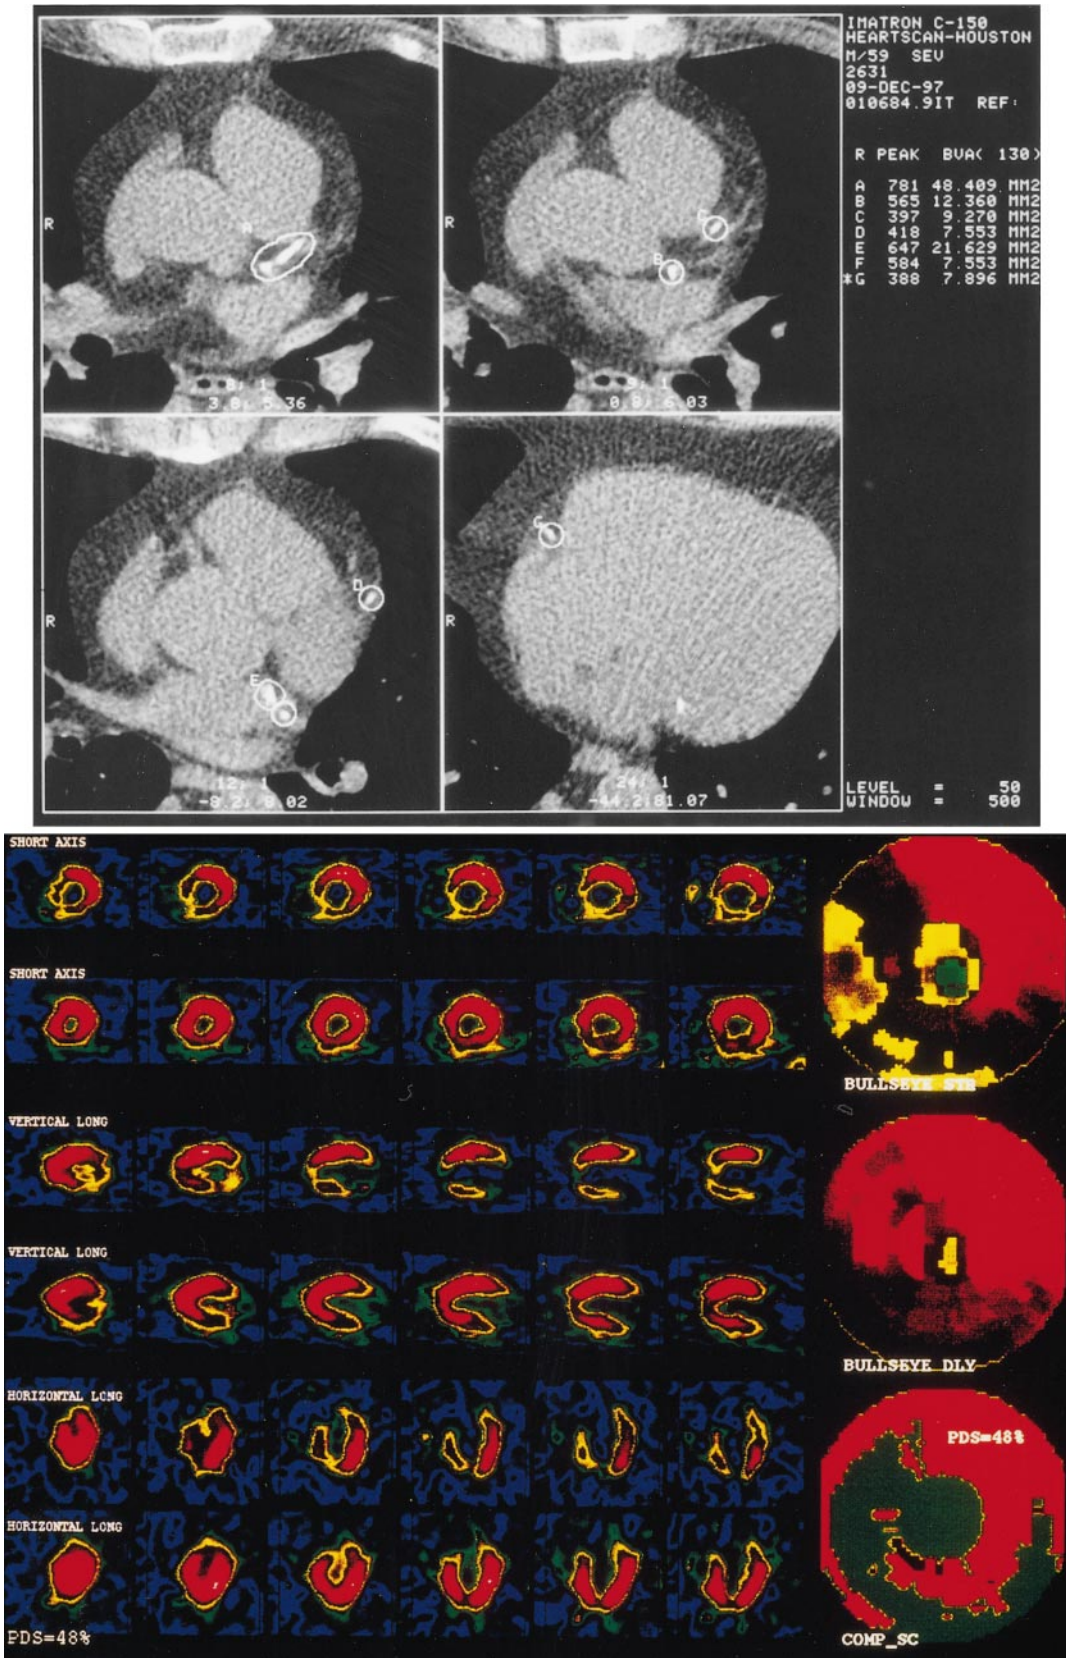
EBCT (top) and SPECT (bottom) images of asymptomatic subject who had high-risk CACS of 937. Circles define regions of coronary calcification. Upsloping (<1 mm) ST-segment depression occurred 9.0 minutes into ETT, which was terminated because of patient fatigue. Although Duke score was calculated as low risk (6.5), SPECT demonstrated large, reversible 48% perfusion defect (green) within distribution of all 3 major coronary arteries (COMP-SC) (bottom). This patient had severe 3-vessel disease on angiography and underwent CABG. PDS indicates perfusion defect size.
